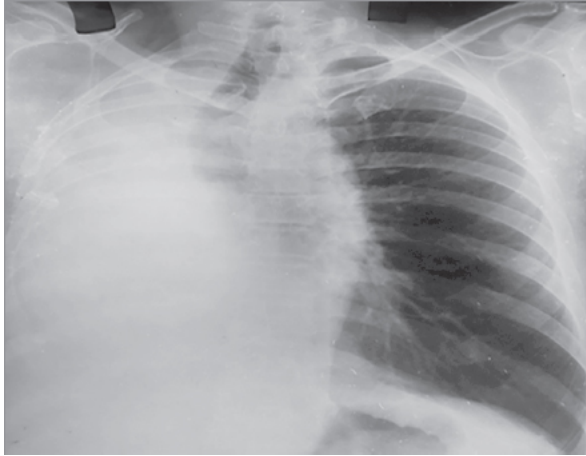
Chest X-ray PA view showing homogeneous opacity on the right hemithorax with trachea shifted to same side suggestive of right-sided collapse/pneumonectomy.
